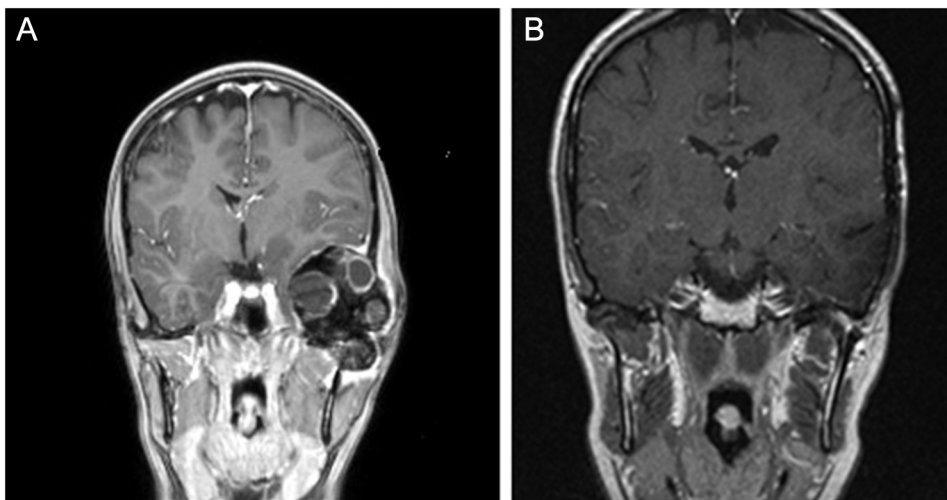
(A) MR images of a 20-year-old female with TGCT-TMJ on the left (patient 1). Preoperative MR images demonstrating a large solid multilobular mass in the infratemporal fossa with extension into the left temporal bone. An increased pressure on the temporal lobe was seen. No malignant characteristics were shown. (B) MR images of a 20-year-old female with TGCT-TMJ left sided, 1 year postoperatively (patient 1) after TGCT-TMJ resection on the left side. There is minimal residual coloring around the TMJ, indicating scar tissue or reactive, without visible hemosiderine deposits.
